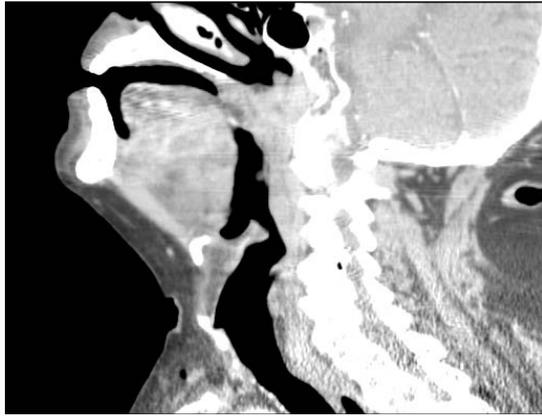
Sagittal CT scan of the neck disclosing abscess at the 2/3 posterior of the body of the tongue.
